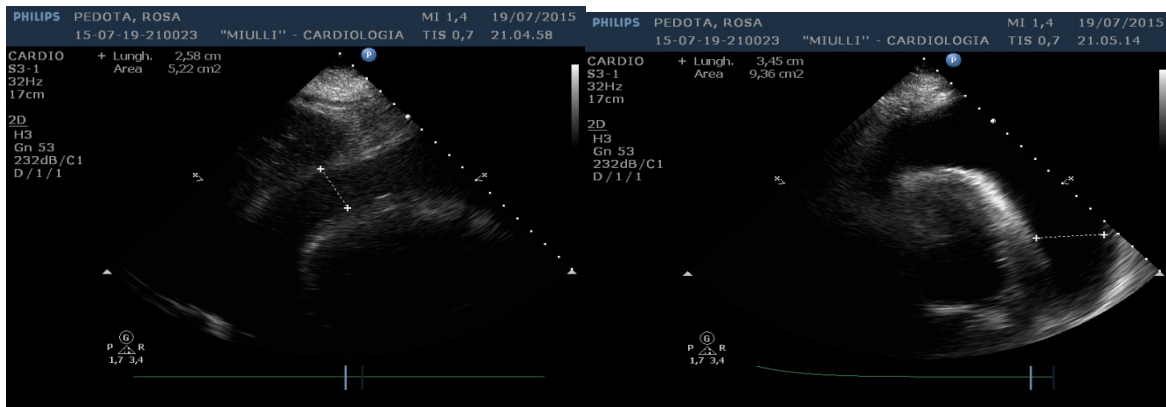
Echocardiogram: severe pericardial effusion (“Swimming Heart”).
